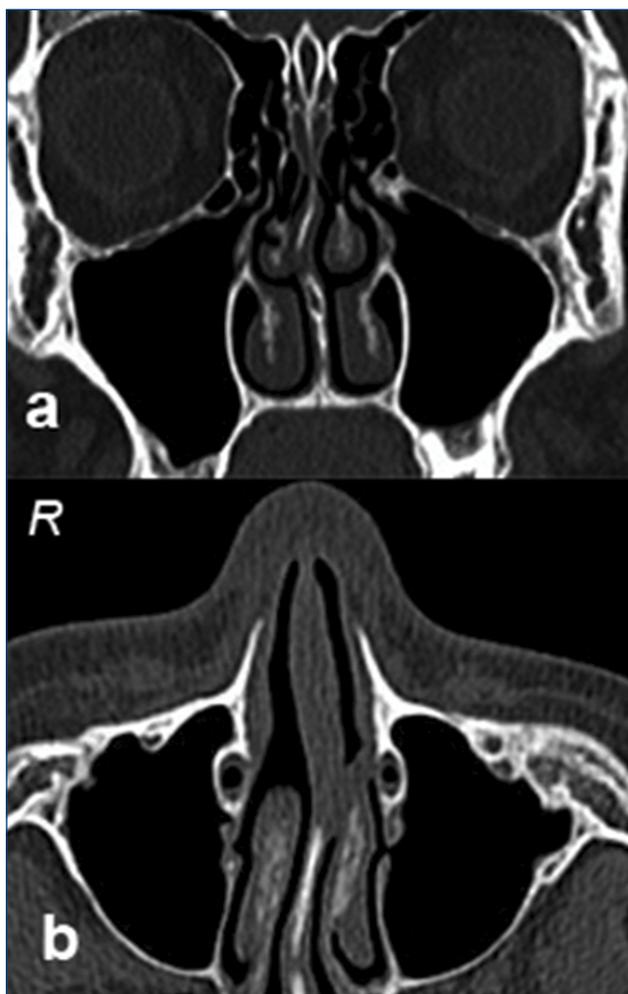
Paranasal CT sections of a 13-year-old boy with bilateral Haller cell and left accessory maxillary ostium. a) coronal section b) axial section
